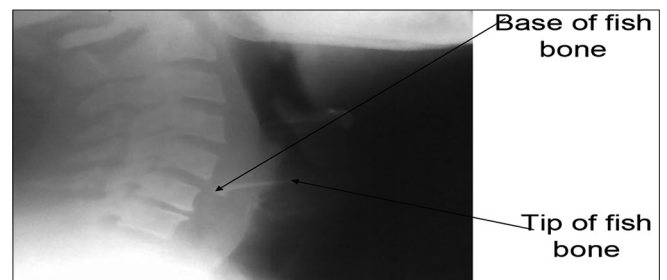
X-ray showing penetration of fish bone into trachea
